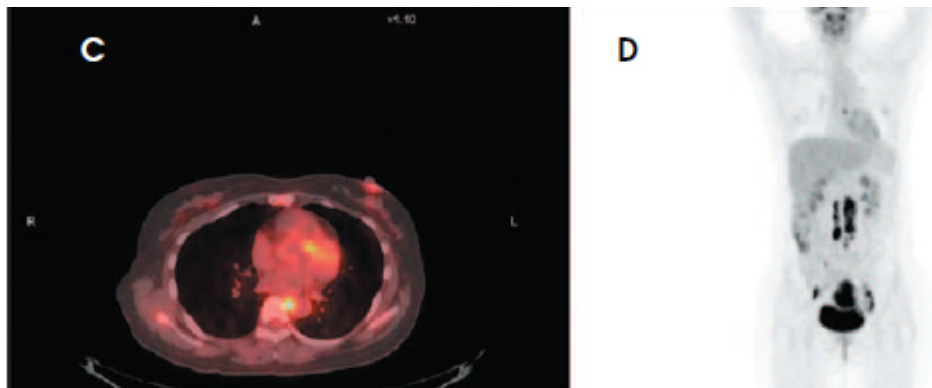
Images from a patient with cervical cancer: (A) axial CT scan, (B) FDG-PET image, (C) fused PET/CT image, and (D) an anterior maximum intensity projection (MIP) image. Distant metastasis of cervical cancer to a paraesophageal node was evident on the FDG-PET (B) and PET/CT image (C), that was not detected on a diagnostic CT scan, performed previously (not shown). The anterior MIP image (D) showed extensive disease burden in the pelvis, as well as retroperitoneal adenopathy (1).
